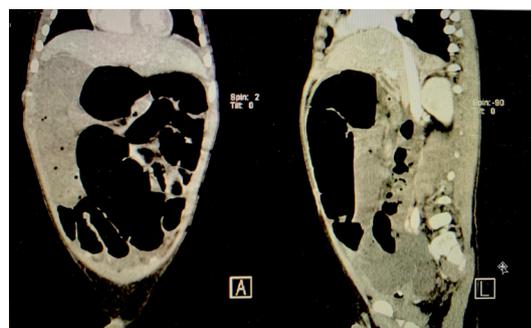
Abdominal CT shows severely dilated ileal loops with air-fluid levels, compatible with small bowel obstruction.
